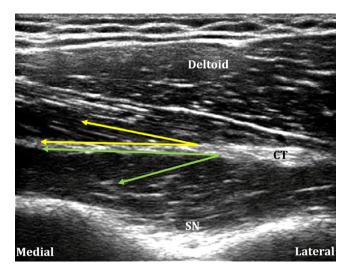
Ultrasound image of the infraspinatus, with *indicating the superficial* infraspinatus pennation angle and *infraspinatus pennation* angle. *CT*, central tendon; *SN*, suprascapular notch.
